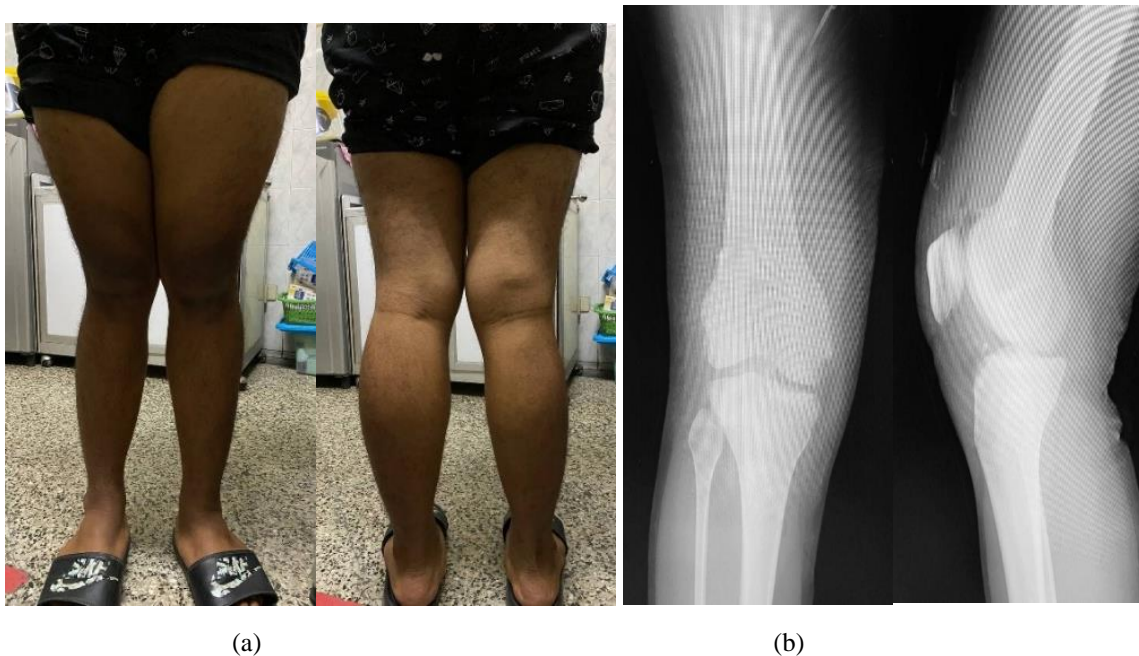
(a) Clinical lower extremity photo before the first surgery; (b) Anteroposterior and lateral radiograph after the first surgery.
